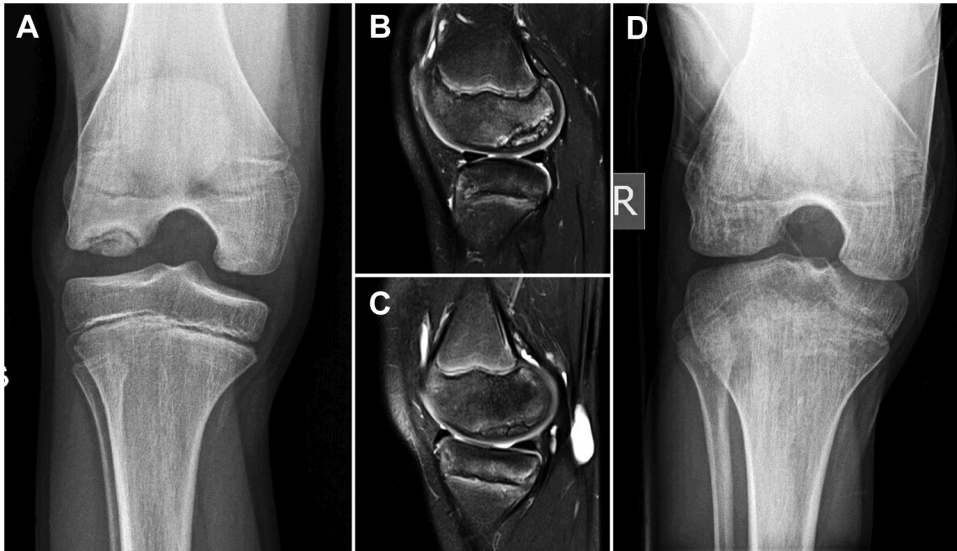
Imaging in a 12-year-old boy with a 1-year history of bilateral knee pain and osteochondritis dissecans unresponsive to nonoperative treatment. (A) Two lesions in the right knee were evident on the preoperative tunnel view. (A, B) Sagittal T2-weighted magnetic resonance images showed a 25 × 15-mm lateral femoral condyle lesion (B) and 23 × 12-mm medial femoral condyle lesion (C). The observation of no breaks in the articular cartilage suggested a stable lesion, which was confirmed on arthroscopic examination. (D) At 1 year postoperatively, both lesions were completely healed; the patient was pain free and had returned to sports activity. Of note, this patient had a fraternal twin who also had bilateral knee osteochondritis dissecans. (R, right.)
